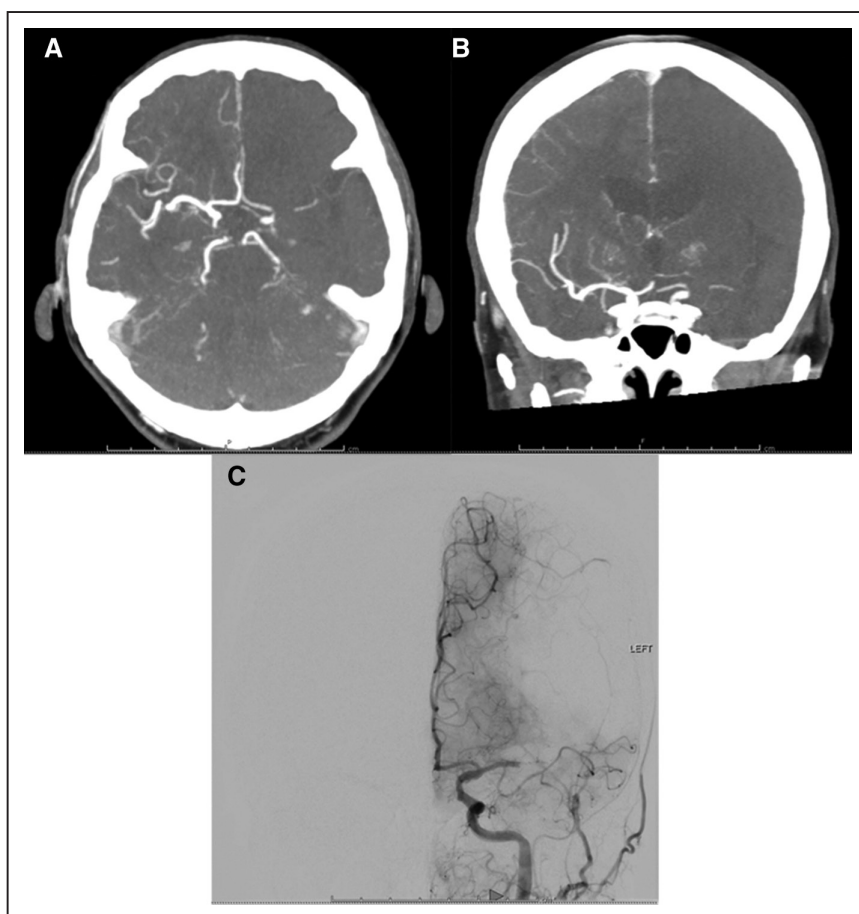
Example of clot migration comparing computed tomography angiography (CTA) to digital subtraction angiography (DSA). A and B, axial and coronal CTA indicated clot located in left internal carotid artery terminus junction. C, Coronal DSA indicated clot migrated to M1 segment of left middle cerebral artery (MCA).
